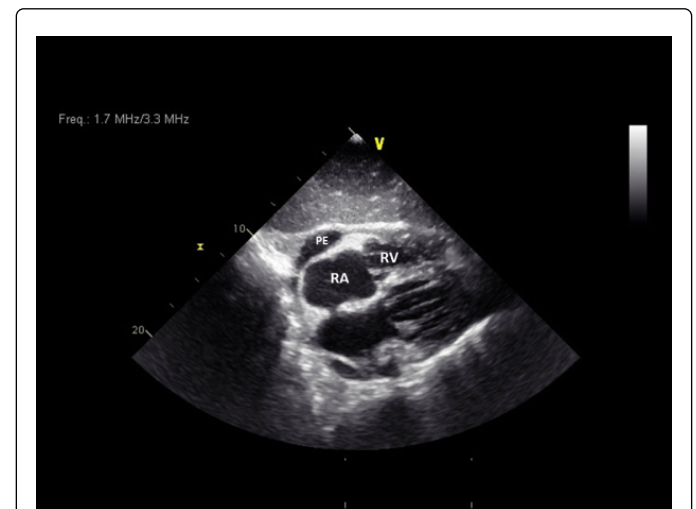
(A) Thoracic CT scan, showed a left-sided pleuric effusion (\*), pericardial metastasis (arrowhead) and small pericardial effusion (arrows); (B) Transthoracic echocardiogram (subcostal 4 chamber view) revealed a large pericardial effusion (PE) with diastolic collapse of the free right ventricular wall (head, RV). RA= right atrium; RV= right ventricle; PE= pericardial effusion
